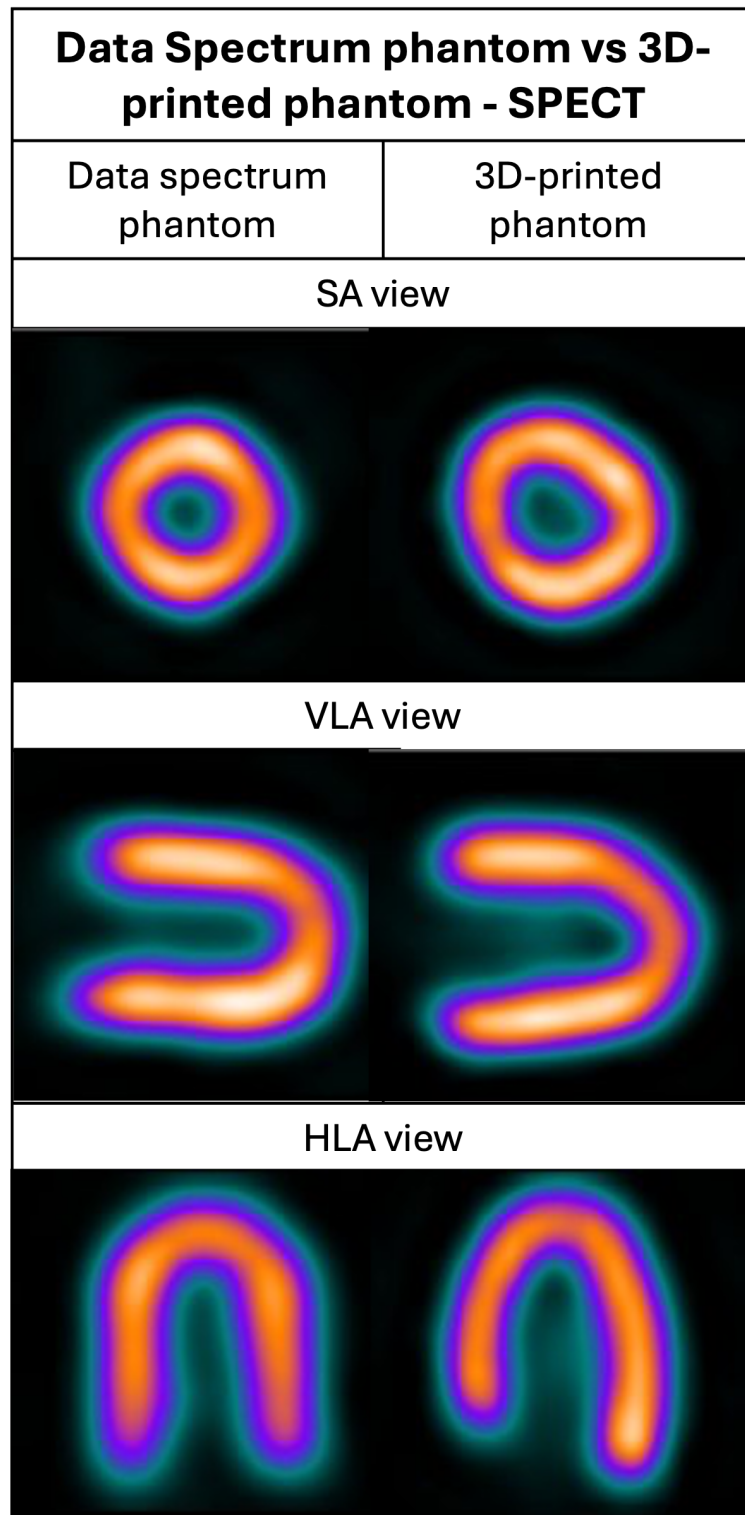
SA, VLA and HLA views obtained through imaging with SPECT
